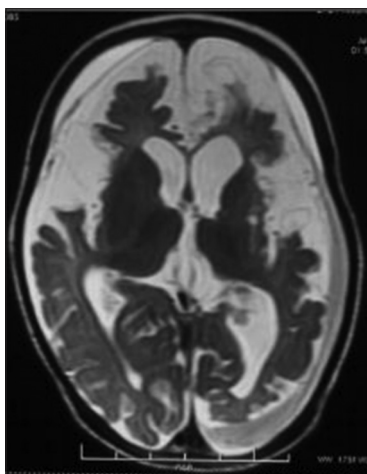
MRI brain T2-weighted axial scan showing open opercula giving a bat-wing appearance, white matter abnormalities, and bilateral subdural hemorrhage suggestive of glutaric aciduria 1
